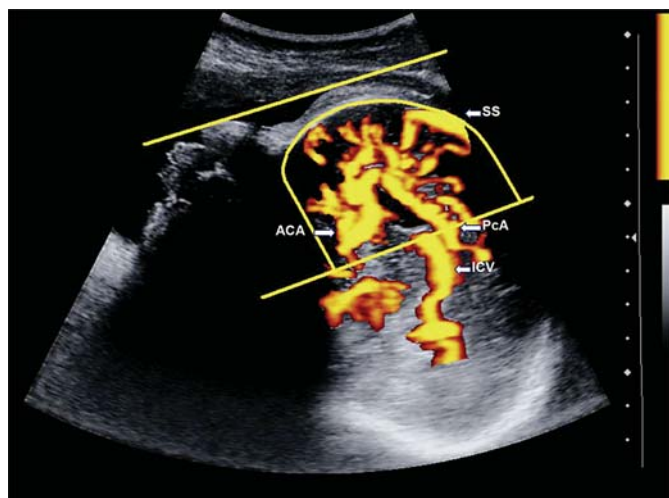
Power Doppler image from the region of interest, where frontal lobe perfusion was estimated. ACA = Anterior cerebral artery; SS = sagittal sinus; PcA = pericallosal artery; ICV = internal cerebral vein.
